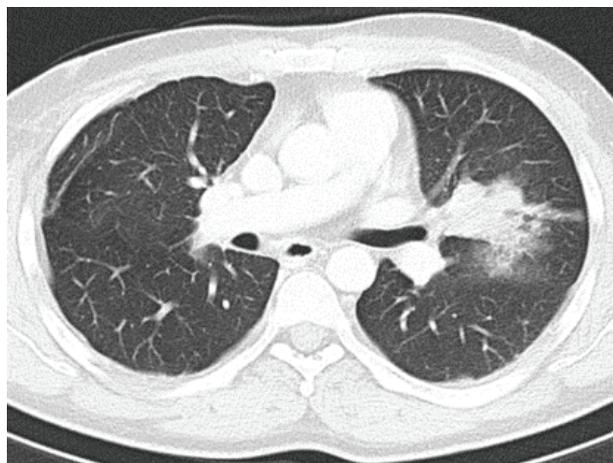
Chest CT of December 29, 2015. Relapse of hemorrhage into both lungs parenchyma
